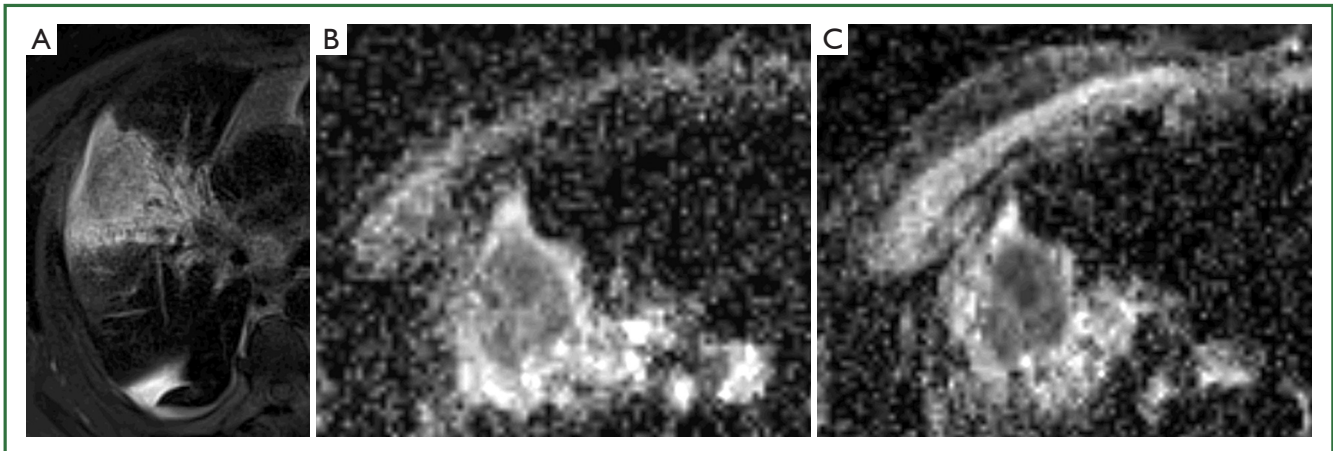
A 71-year-old man with Stage III NSCLC in the right upper lobe. A. Axial T2-weighted MR image shows a heterogeneous T2 hyperintense mass with surrounding atelectasis; B, C. Axial ADC diffusion images before (B) and 24 hours after (C) starting chemotherapy show reduced ADC signal intensity in tumour following treatment.
